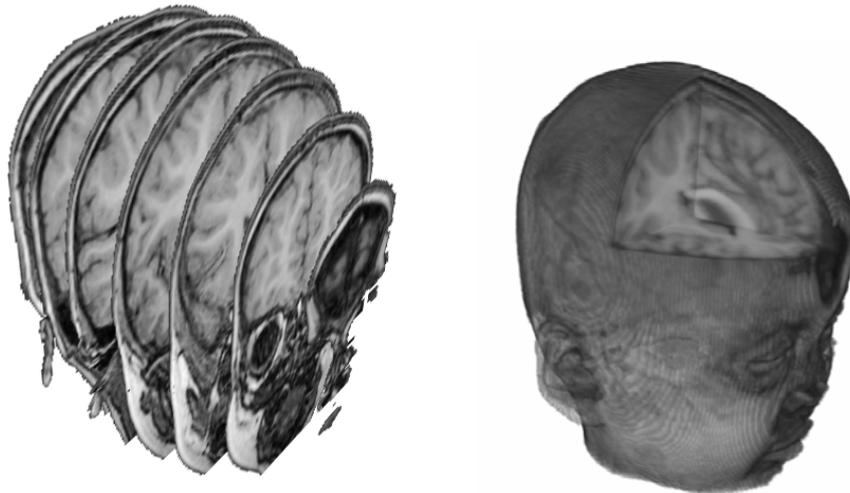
Volume visualisation methods of a human head (MRI): volume slicing (left), volume rendering (right)
